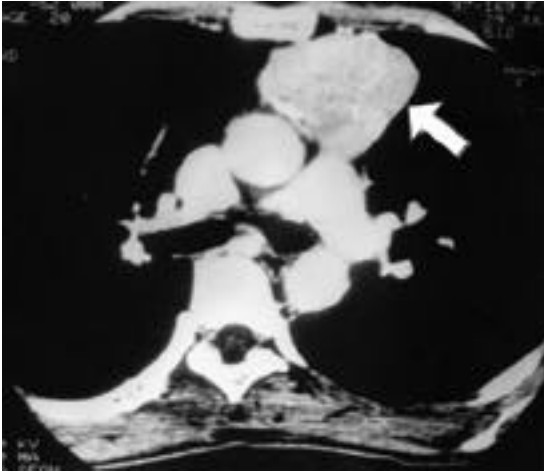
The CT scan shows about 6×5cm sized solid mass which contains curvilinear multiple calcification in anterior mediastinum and no evidence of aortic or pulmonary artery invasion.
